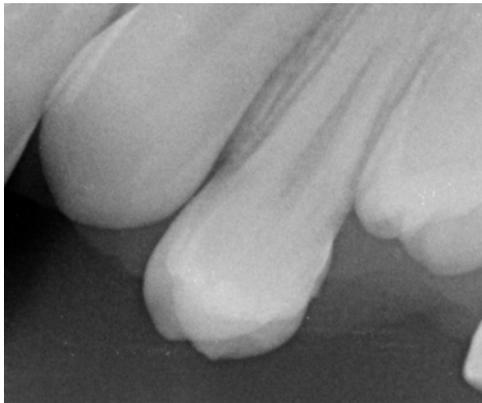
The periapical radiograph of the related area. The abnormal structure could not be clearly observed.
